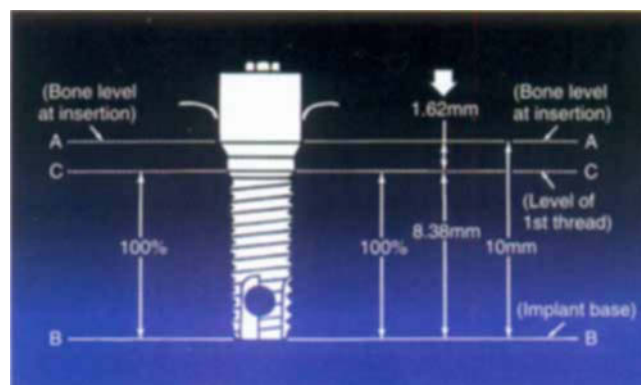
■ Bone loss of 1.62 mm from ridge crest to depth of first thread of fixture between insertion and radiographic evaluation in Goteborg study. (Modified from Branemark PI, Zarb GA, Albrektsson T, editors: *Tissue-integrated prostheses: osseointegration in clinical dentistry*, Chicago, 1985, Quintessence.)
